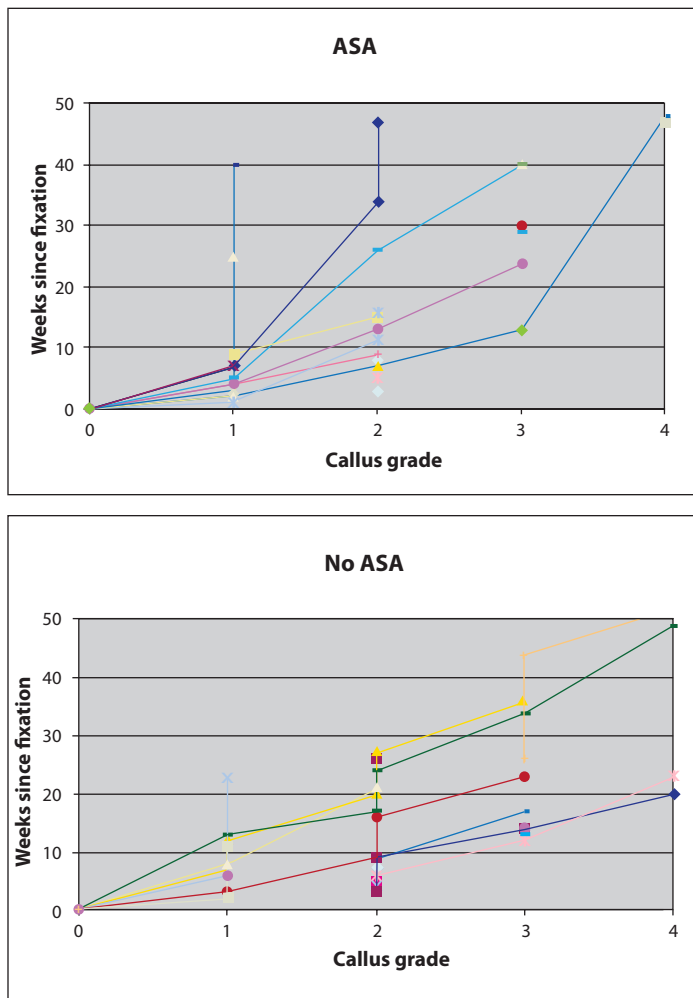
Fracture callus grade as a function of time since fixation was plotted as a function of time. Each point represents a grading event based on a set of follow-up x-rays. Each line represents a single patient.
